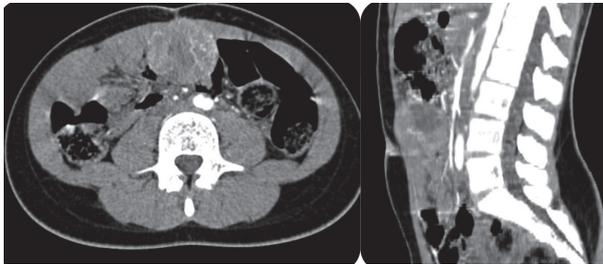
Abdominal computed tomography angiography (CT) revealing an umbilical intra-peritoneal tumor (50 x 40 x 45 mm) with well-defined limits, heterogeneous, predominantly solid, highly vascularized, predominantly from the lower epigastric vessels.
